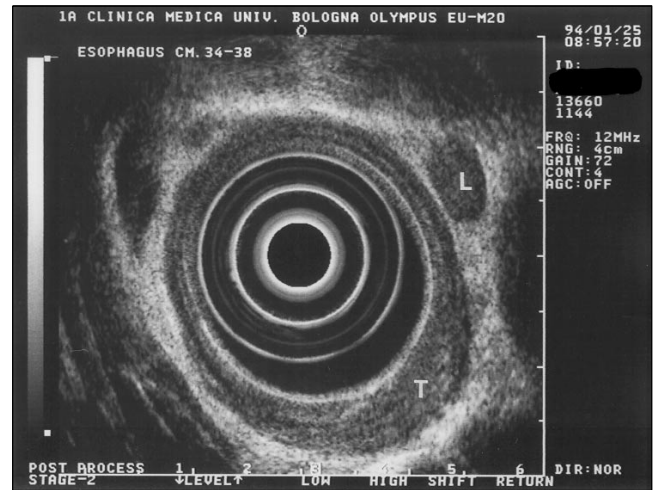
Endoscopic ultrasonography (EUS) radial scanning at 12 MHz of a T2 N1 esophageal cancer (T). A large and well demarcated lymph node is displayed outside the esophageal wall (L)
